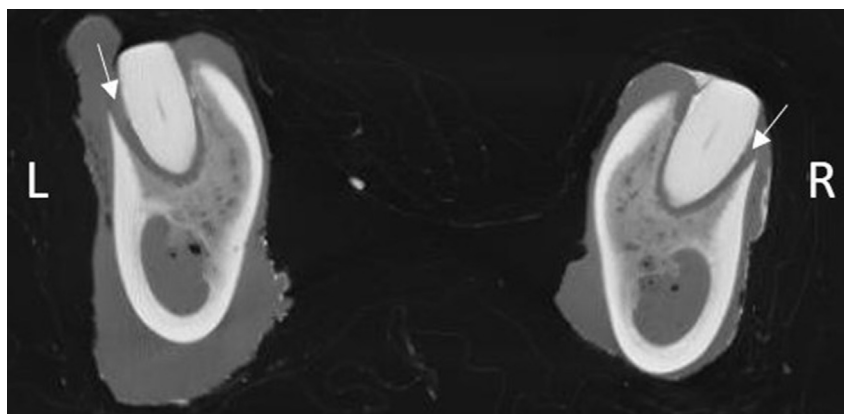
Transverse CT image showing teeth L11 (L) and R11 (R), both of which were presumed vital (at the time of death) based on their uniformly narrowed pulp cavity. Both show evidence of severe abrasion and have buccally-widened periodontal ligament spaces (white arrows) with alveolar bone loss, consistent with a form of periodontitis classified as vertical bone loss.
